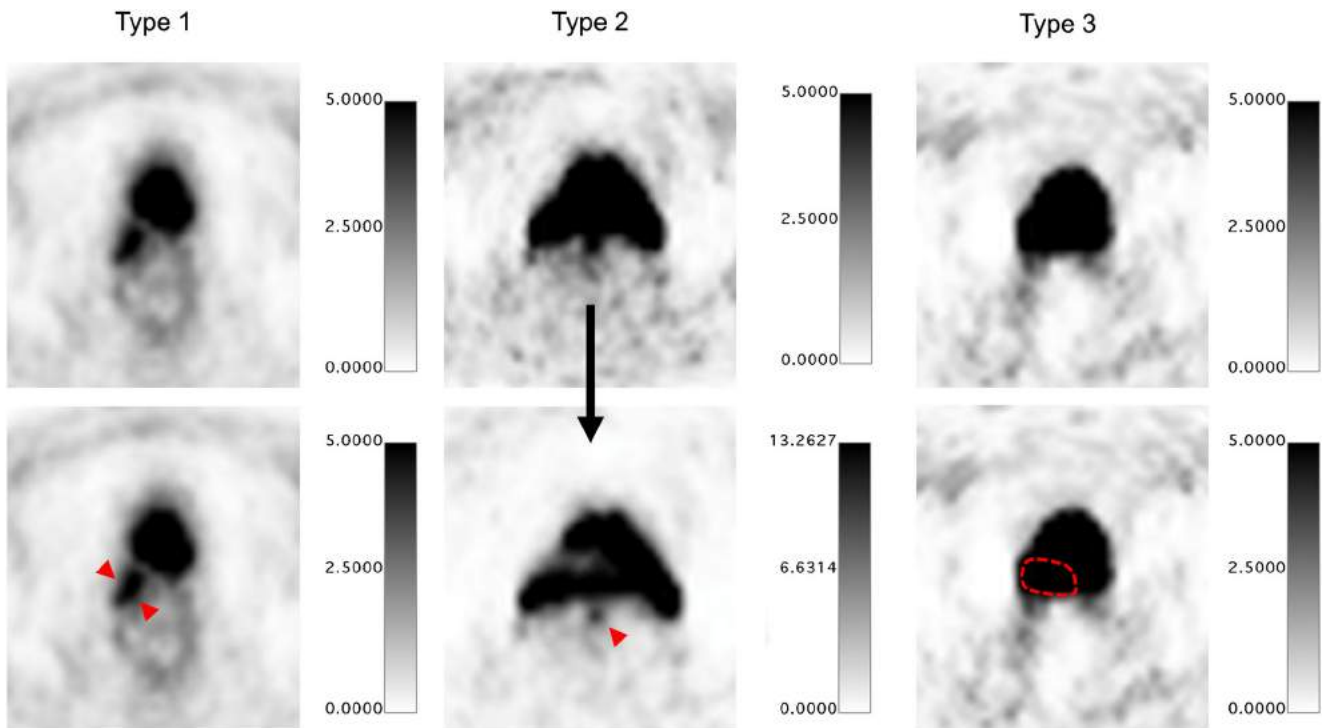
Classification of LRs depending on proximity to the bladder. Classification of LRs depending on PET-positivity. Type 1: recurrence (red arrow heads) is depicted as a separate signal in standard windowing [0 - 2.5 - 5 SUV]. Type 2: Fusion of PET-positive recurrence (red arrow
